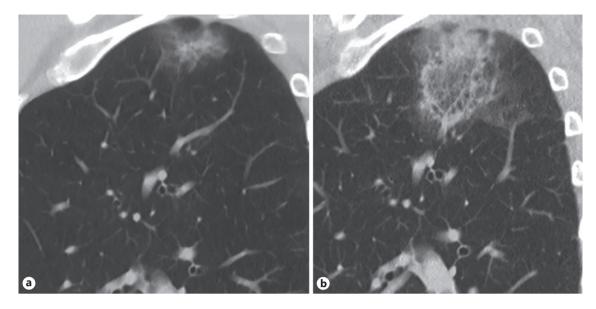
a Sagittal CT image of RUL part-solid lesion in apical RUL. b Wedge-shaped opacity demarcates the post-ablation treatment zone.
